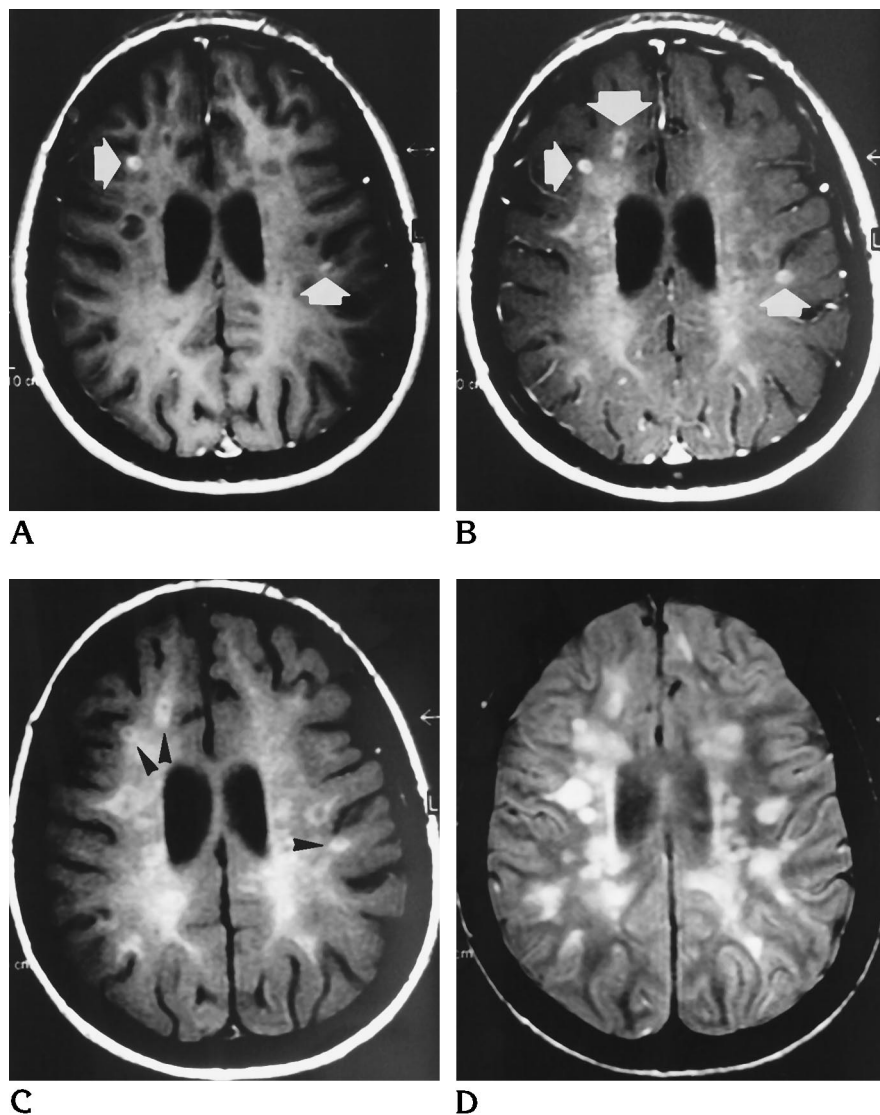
Contrast-enhanced conventional T1-weighted spin-echo MR image (A) and MT T1-weighted image (B). Note hyperintense round lesion in B, indicating the presence of an enhancing plaque. Other hyperintense areas are seen in the cerebral white matter. The round lesion, as well as the others, are not visible on the contrast-enhanced conventional image (A) but are clearly identified on the unenhanced MT T1-weighted image (C). This suggests a lower MT ratio of these lesions rather than true enhancement. The lesions are hyperintense on the proton density-weighted image as well (D).
